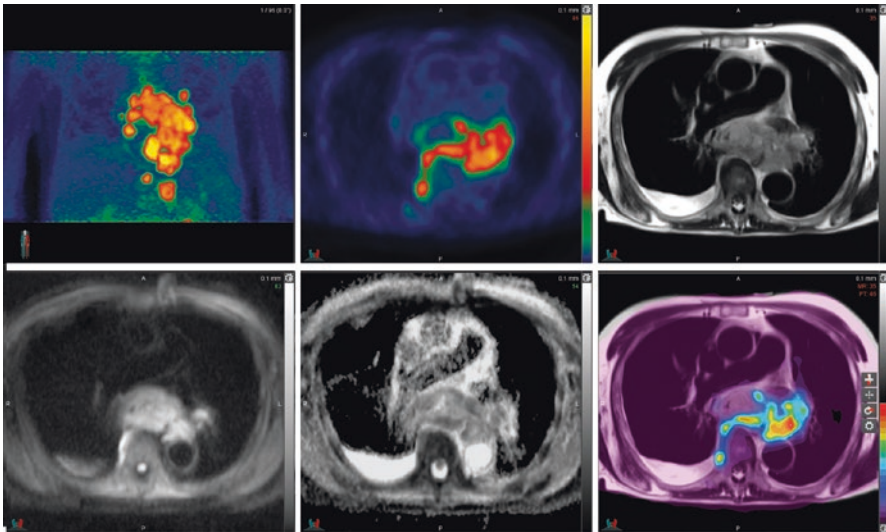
85-year-old male with newly diagnosed diffuse large B-cell lymphoma. FDG PET/MRI demonstrates large mediastinal mass in the posterior mediastinum. Intense FDG uptake (upper middle frame) is seen corresponding to hyperintense foci on diffusion-weighted images (lower left frame) with corresponding relatively low ADC values (lower middle frame; see dark regions anterior to spine and aorta)
